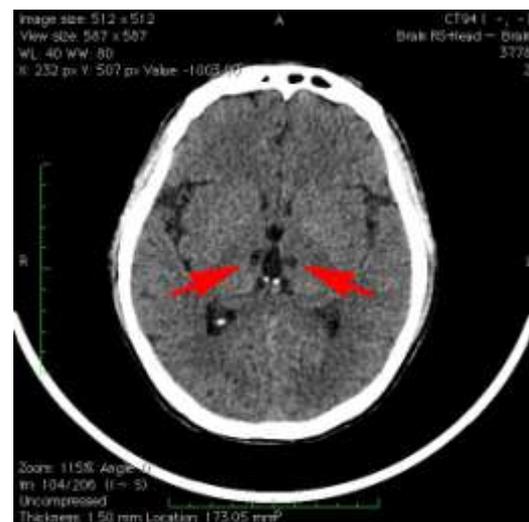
Head CT scan demonstrating a small hypodense lesion in bilateral paramedian thalamic (red arrows)
